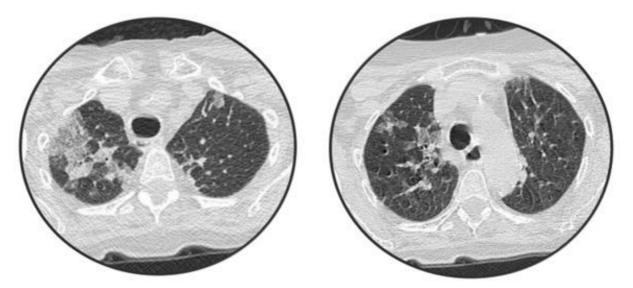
Computed tomography of the chest without contrast, with signs of PID.
